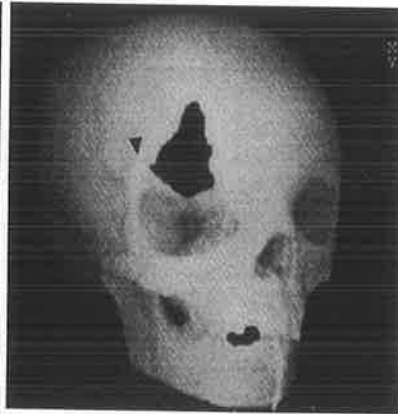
Three-dimensional CT view of the suprolateral orbital rim notching of the number 9 cleft separate from the larger frontal defect of the number 10 cleft.
